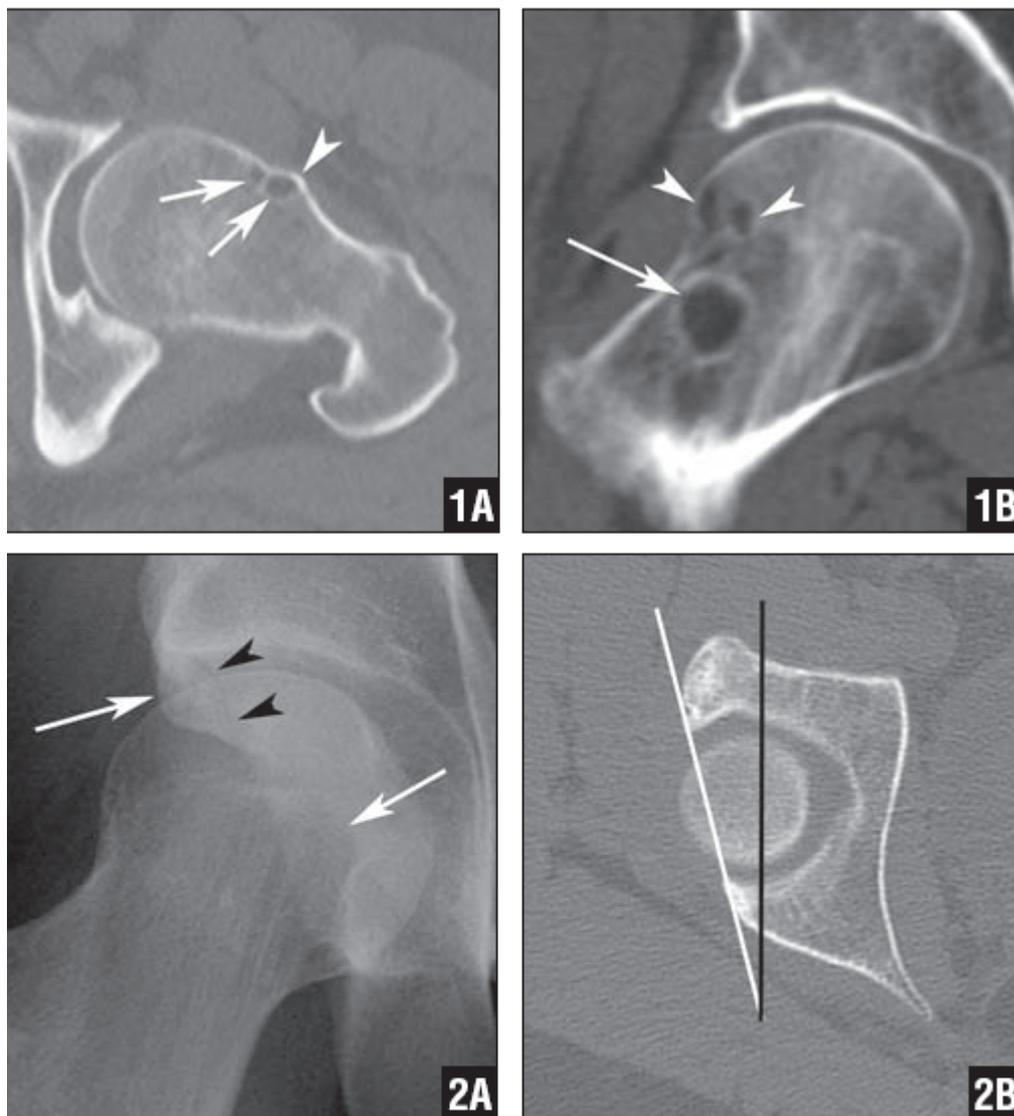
Femoral neck herniation pits (A). CT through the left hip demonstrates two small anterior femoral neck herniation pits (arrows) and a small protuberance at the femoral head/neck junction (arrowhead). Findings are compatible with cam impingement (B). Coronal CT reformatted image in a different patient demonstrates a dominant femoral neck herniation pit (arrow) and two smaller anterior femoral head cysts (arrowheads). Figure 2: Crossover sign (A). Frontal radiograph of the right hip demonstrates the 'crossover' or "figure-of-eight" sign, where there is focal retroversion of the superior aspect of the hip joint. The superior aspect of the anterior rim (arrows) of the acetabulum extends lateral to the posterior rim (arrowheads) (B). CT of the same patient demonstrates the retroversion of the superior acetabulum (white line) relative to the sagittal plane (black arrow). Patient had symptoms of pincer impingement.
